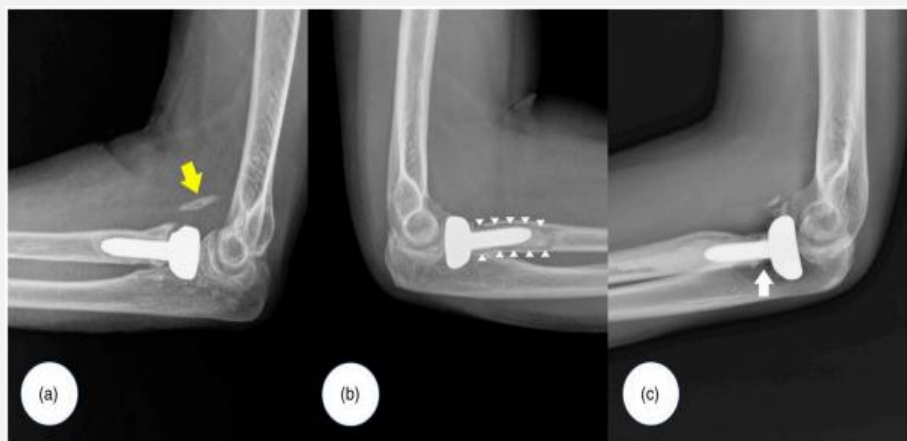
Radiographic results following surgery. (a) Heterotopic ossification (patient 9; yellow arrow). (b) Radiolucency at the contact between bone and cement (white arrow heads) in patient 10. (c) Patient 3's proximal radial neck resorption (white arrow).
